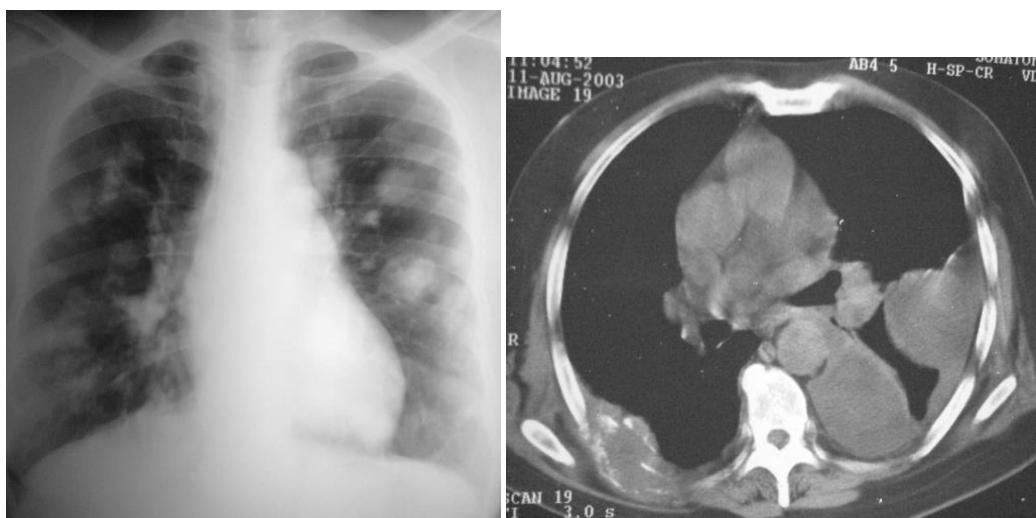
Images of metastases. a. Cannon ball metastasis from choriocarcinoma. b. CT image showing multiple metastasis in the left lung with destruction of a right posterior rib in a patient with bronchogenic carcinoma.
